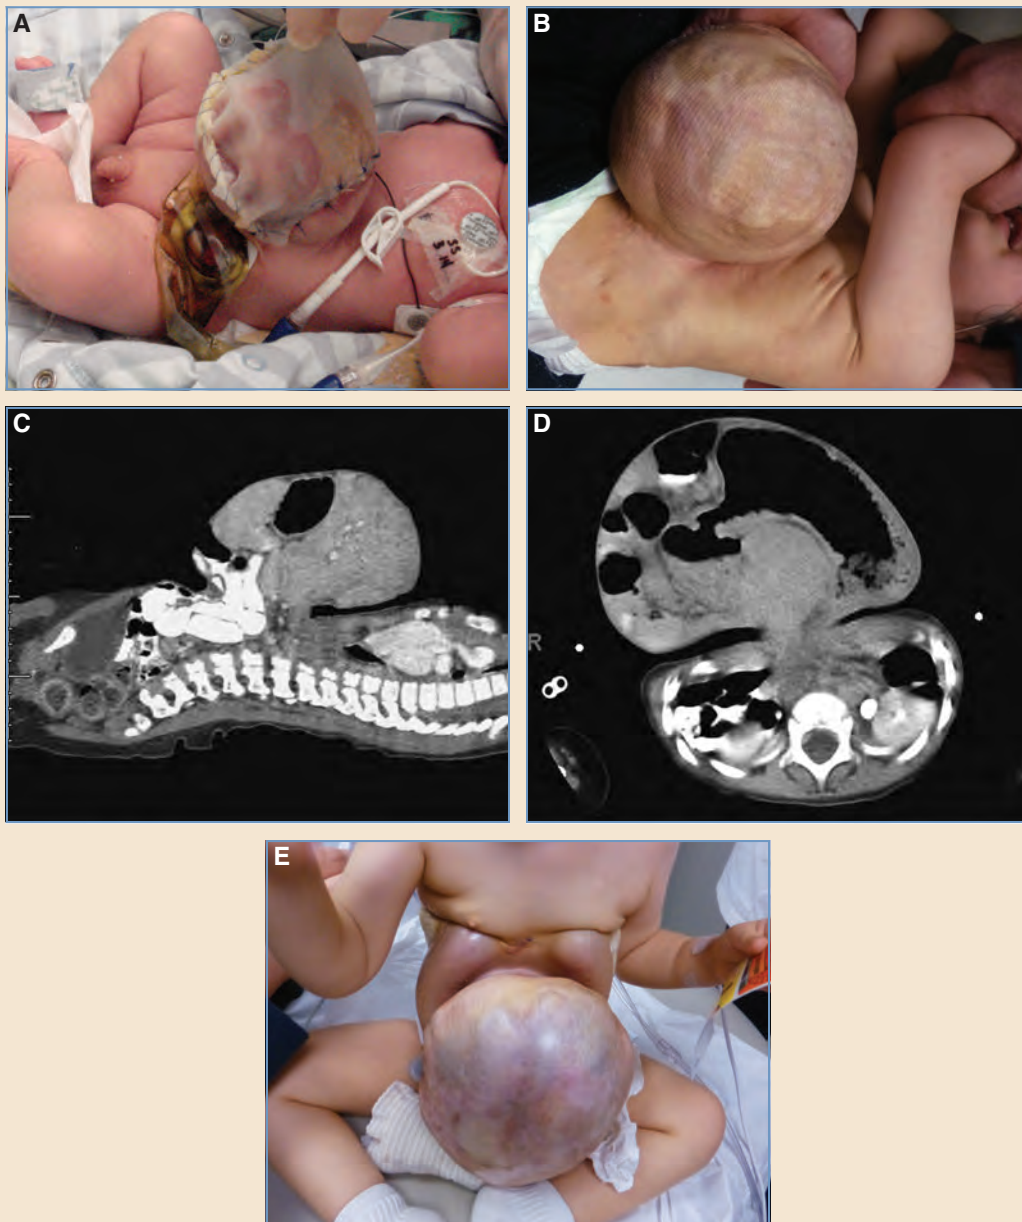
A, A silo was sutured in place. B, He had a giant omphalocele at 2 years of age, with healed skin graft coverage. C, Lateral CT showed the small size of the abdominal cavity versus the large size of the omphalocele. The AP diameter of the abdominal cavity was about 1.5 cm, and the AP diameter of the omphalocele was 9.3 cm. The transverse diameter of the abdomen was 11.8 cm, as opposed to the transverse measurement of the omphalocele of 13 cm. D, Coronal CT demonstrated the discrepancy of the abdominal capacity versus the size of omphalocele. E, The patient is shown 1 month after expander placement.
